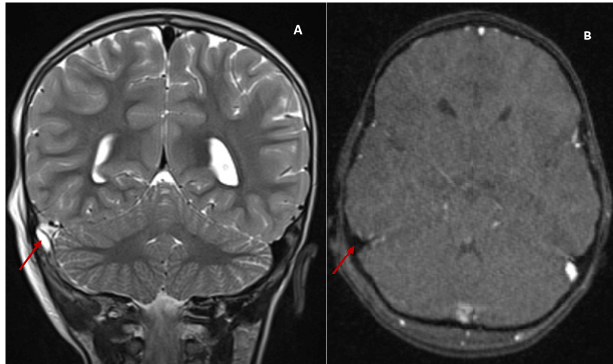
Contrast-enhanced MRI venography of the head. The thrombus is depicted as having increased signal intensity on the T2-weighted coronal phase contrast image (A) and hypointense signal on the T1-weighted axial phase contrast image (B), as indicated by the red arrows. The normal flow of the left sigmoid sinus is depicted by the white arrows.
